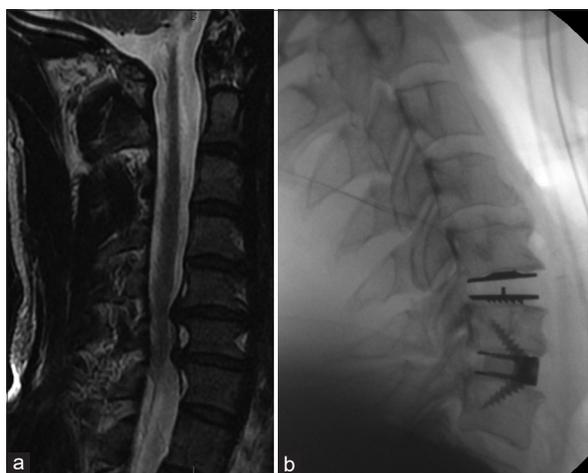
Anterior Cervical Discectomy and Fusion using β TCP/Total Disc Replacement (Mobi-C, LDR, France) hybrid for disc height loss and foraminal stenosis (a) Sagittal MRI of cervical level (b) Intraoperative X-ray
